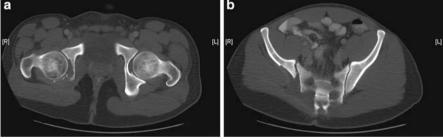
Non-contrast CT images (a, b) using bone windows demonstrating a soft tissue hemangioma causing bony destruction of the acetabulum, ilium and sacrum
